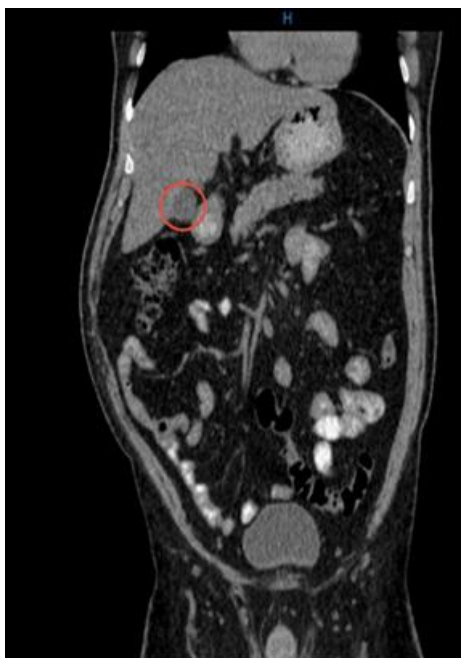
Abdominopelvic CT scan of patient show the mass in right renal fossa
